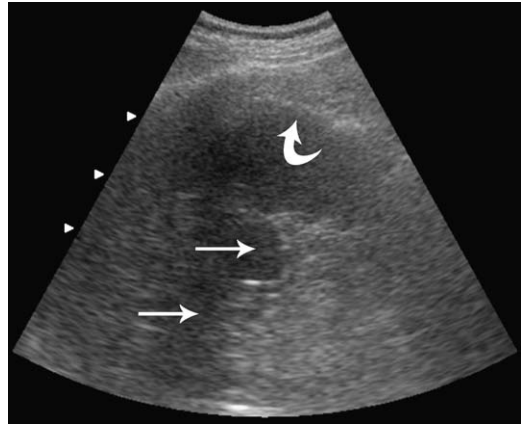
A 71-year-old woman with biopsy-proved metastatic non-small cell lung carcinoma of the left pleural space. Real-time ultrasound of the pleura demonstrates parietal pleural thickening (*curved arrow*) and a soft tissue pleural mass overlying the diaphragm (*arrows*). (Courtesy of Michael Maher, MD, Boston, MA.)
